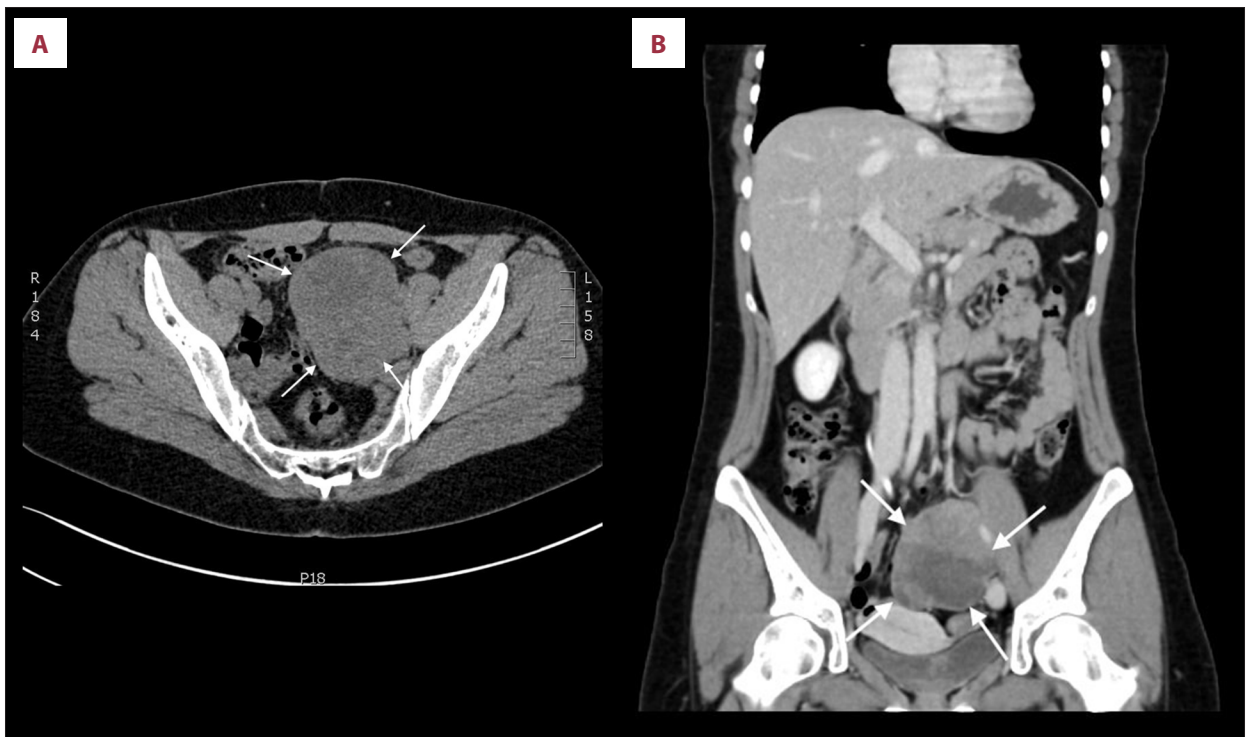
Computed tomography scan showing recurrent tumor (white arrows) on the left side of the pelvis near the iliac vein with cystic and solid components: (A) axial view and (B) coronal view.
